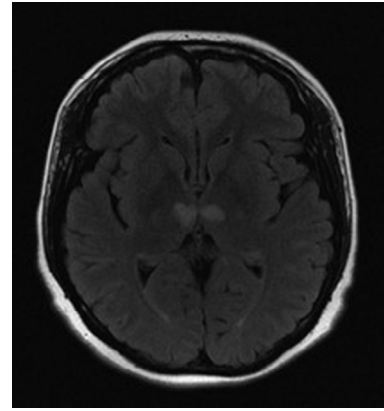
Brain MRI, FLAIR sequences showing a symmetrical bilateral ischemic hyperintensity of the medial part of the thalamus. Abbreviations: FLAIR, fluid-attenuated inversion recovery; MRI, magnetic resonance imaging.
